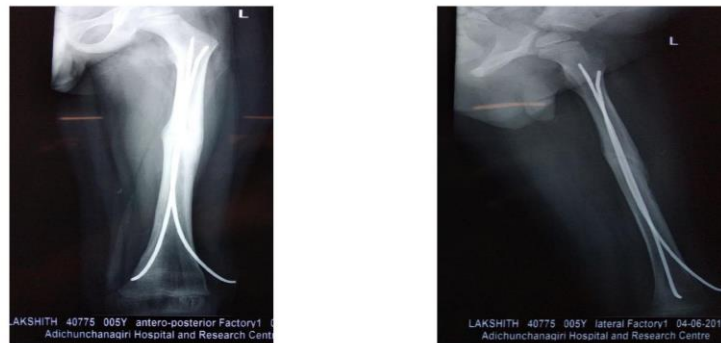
Case 1 - Post-operative 12th week follow-up radiographs demonstrating complete radiological union with abundant periosteal callus bridging the fracture.
